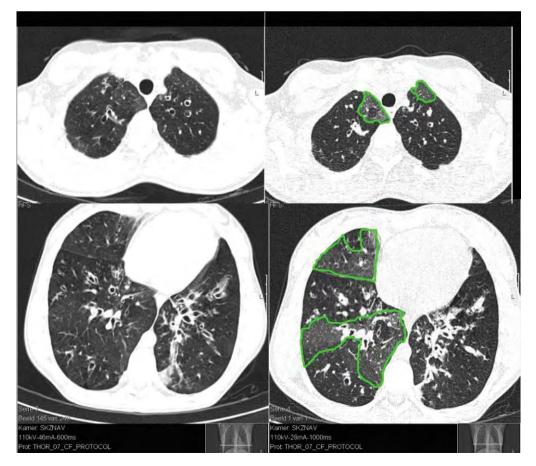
The left two images are selected from a volumetric chest CT examination in inspiration. The two images on the right are taken at identical levels after exhalation. The areas encircled in *green* show an increased density relative to the inflation images. Most of the other areas show near identical density indicating trapped air. Note in addition a barrel-shaped chest. The large anterior posterior diameter is larger relative to the side-to-side diameter. especially for young children who are known to be more sensitive to radiation. A disadvantage of this approach is that it substantially reduces the sensitivity of CT to detect localized structural abnormalities.⁷³ In young children substantial abnormalities can be observed, such as thickened airway walls, narrowed airway lumens, bronchiectasis, and air trapping.⁷¹
